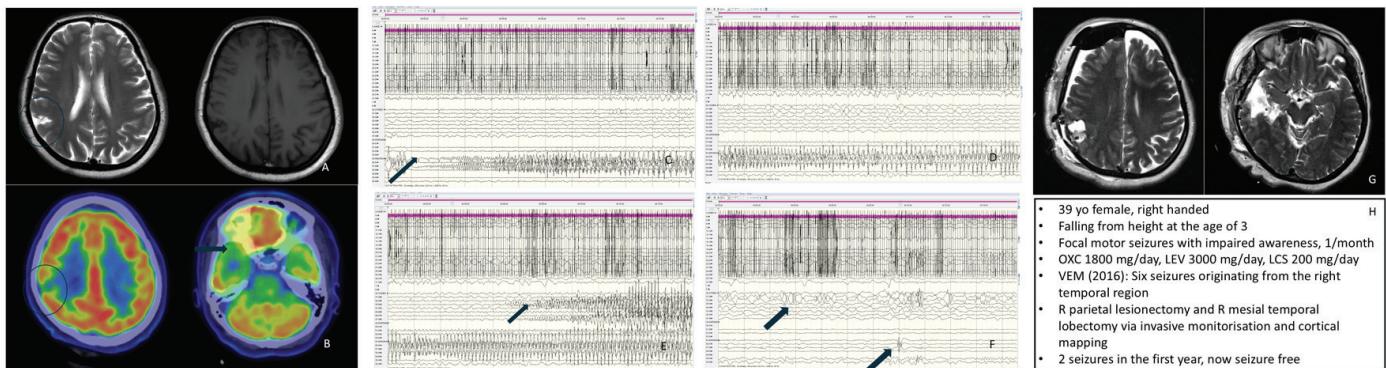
A short case snippet. A) Pre-operative brain MRI showing a T2 hyperintense and T1 hypointense lesion in the right parietal region. B) Brain PET imaging revealing hypometabolism in the right parietal region and pronounced bilateral mesial temporal hypometabolism, more prominent on the right. C,D,E) A seizure originating from the right temporal region electrodes, spreading to the grid electrodes, and becoming generalized during invasive monitoring. F) Invasive EEG monitoring during the interictal period showing independent sharp wave discharges in the right temporal electrodes and the grid electrodes over the parietal lesion. G) Post-operative brain MRI showing encephalomalacic areas consistent with right parietal lesionectomy and right temporal lobectomy. H) short case summary
